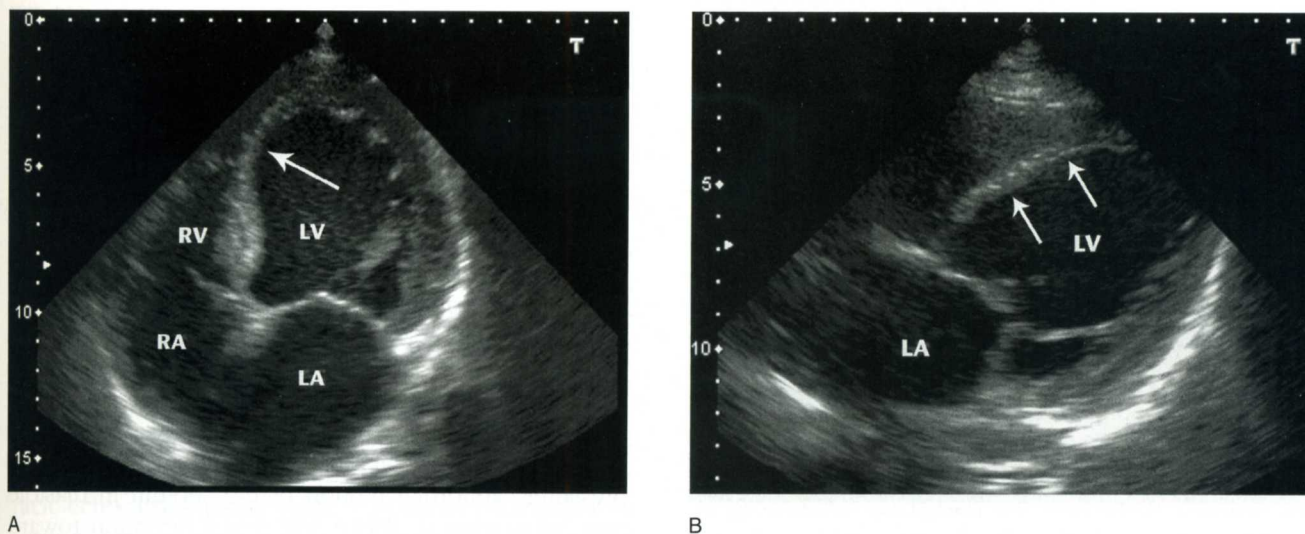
Chronic left ventricular infarction. Apical four-chamber view (A) demonstrates thinning and increased echogenicity of the apical septum (arrow) with increased size of LV and LA chambers. Subcostal four-chamber view (B) shows chronic thinning of the entire inferior septum (arrows). RV = right ventricle, RA = right atrium, LV = left ventricle, LA = left atrium. (Courtesy of Hennepin County Medical Center)
